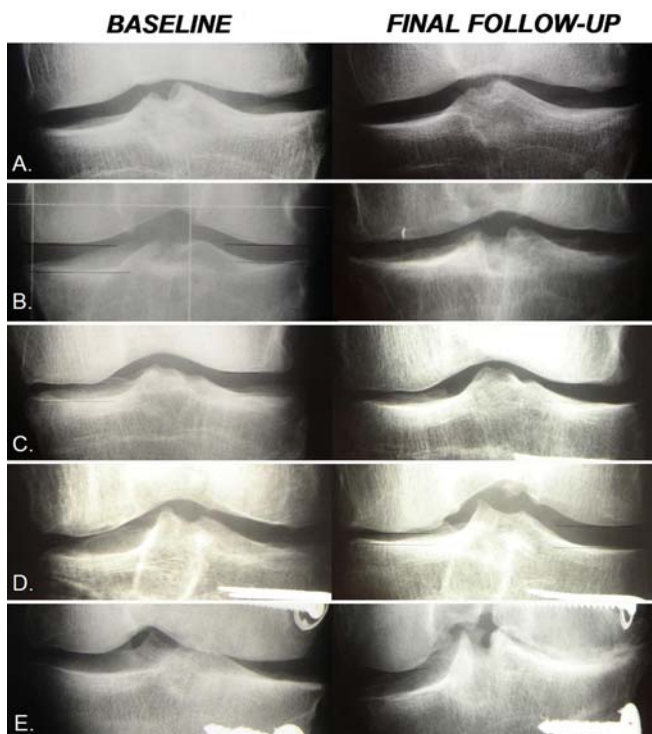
Details of the joint space on standing postero-anterior plain radiographs at baseline (radiographs taken within 6 months of the transplantation) and at the final follow-up (> 10 years). Variable progression of joint space narrowing (graded according to IKDC) is seen during the follow-up. *Patient A* (LMT): no progression, *patient B* (MMT): minimal progression by one grade, *patient C* (MMT + HTO): progression by one grade, *patient D* (MT + HTO, previous ACL): progression by two grades, *patient E* (LMT): progression by three grades
